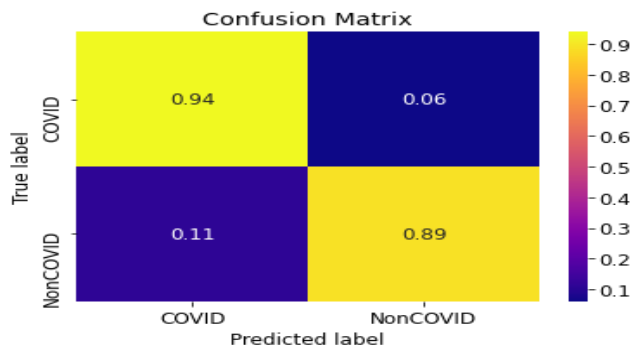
Confusion Matrix of Xception model for X-Ray images
